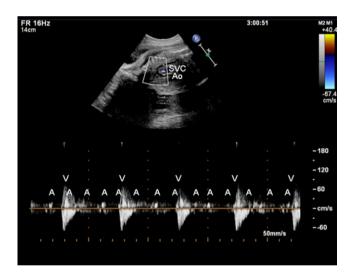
Simultaneous pulse wave Doppler of the aorta and vena cava superior of a fetus with complete heart block showing backflow following atrial contractions (A) in the superior vena cava with an atrial rate of 140/min (A) and in the same direction aortic outflow following ventricular contractions (V) which are independent with a regular rate of 60/min.
